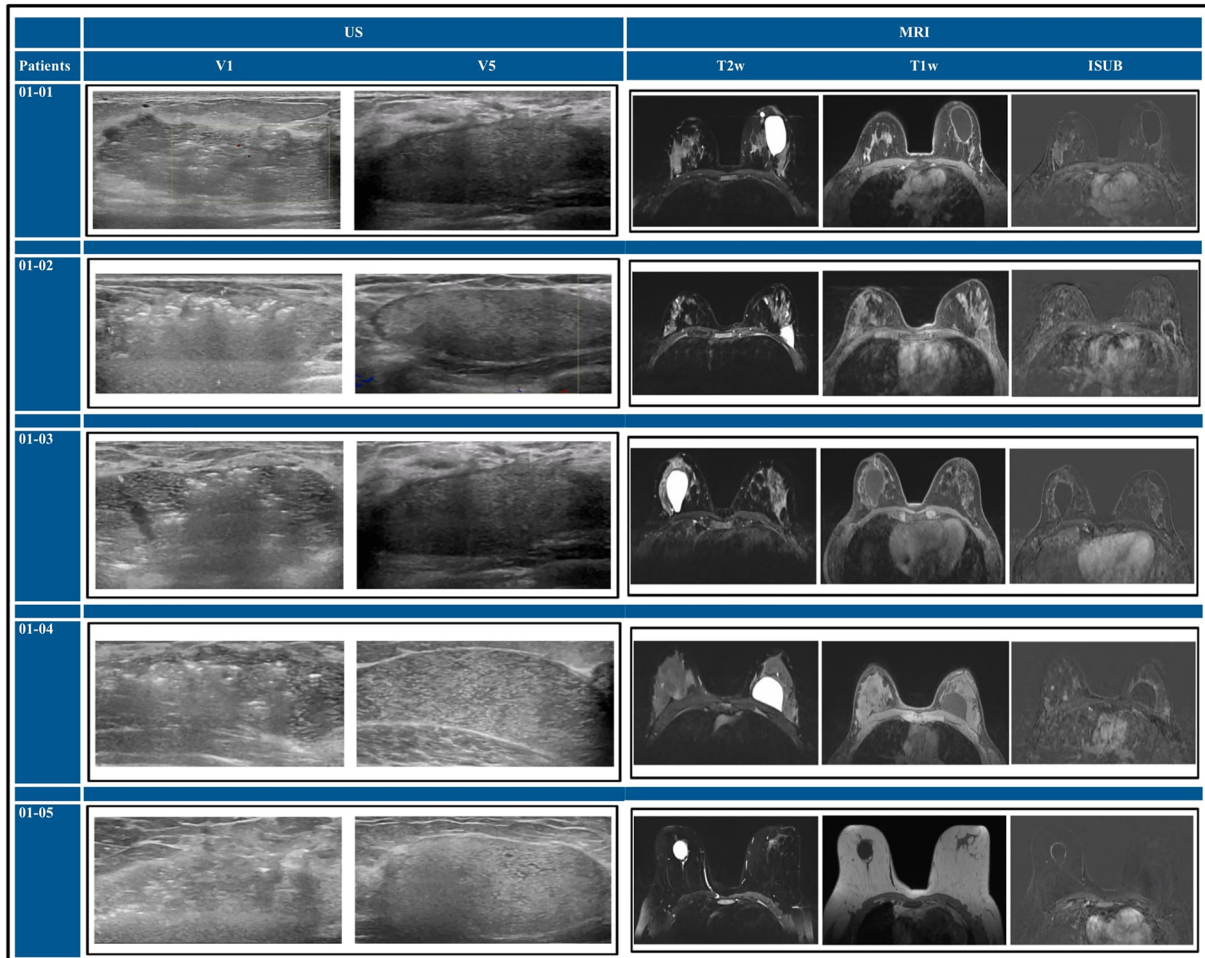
US and MRI imaging: Findings at 1 week from surgery (V1) and after six months (V5)
